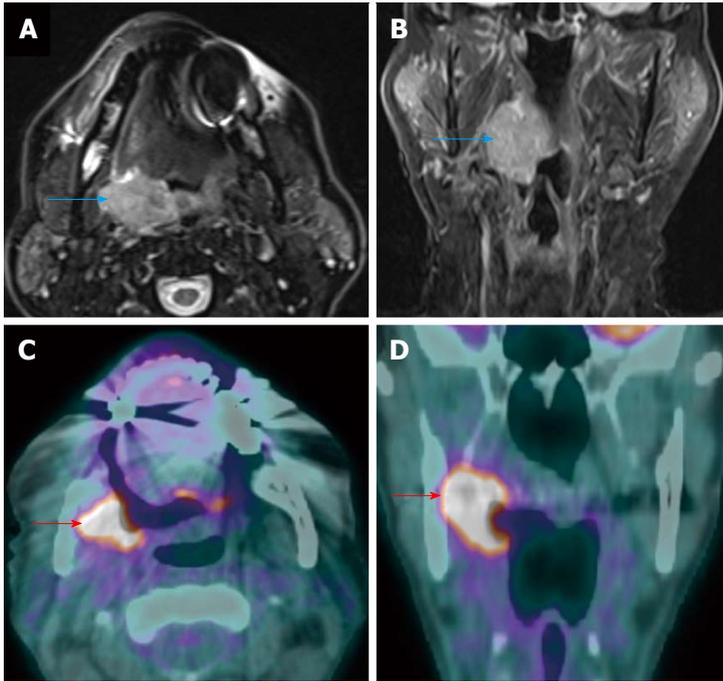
Recurrent primary tumor detected by positron emission tomography/computed tomography. A T3N0M0 right palatine tonsil squamous cell carcinoma was demonstrated on axial T2W magnetic resonance imaging (MRI) (blue arrow) (A) and coronal contrast-enhanced T1W MRI (B). MRI and positron emission tomography/computed tomography (PET/CT) performed 2 and 3 mo after completion of chemoradiation demonstrated complete treatment response (not shown). Surveillance PET/CT (C and D) revealed intense increase metabolism in the right palatine tonsil and medial pterygoid muscle (red arrows) representing a recurrent squamous cell carcinoma.
